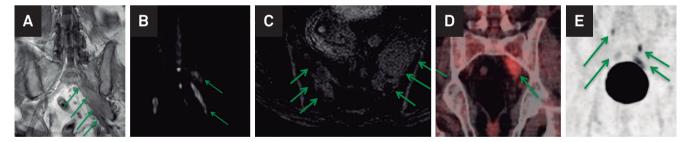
Neuroimaging of the sacral plexus. Sacral plexus MRI coronal T1 WI (A), coronal DWI (B) and axial T2/STIR (C) images also show fusiform masses along the sacral plexus roots and trunks (arrows). PET-CT coronal (D and E) show sacral plexus fluorodeoxyglucose hypermetabolism.
